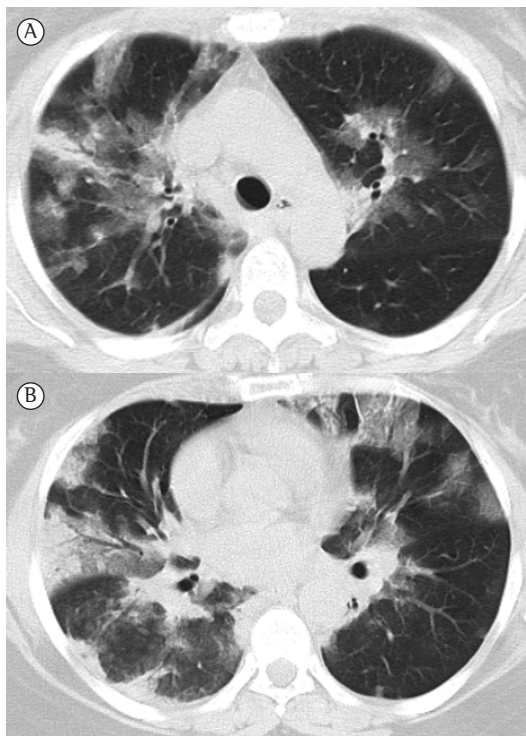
HRCT scans. In A, areas of consolidation and ground-glass opacities in the upper lobes of both lungs. In B, areas of consolidation and ground-glass opacities in the lower lobes, with peripheral distribution of the lesions.
